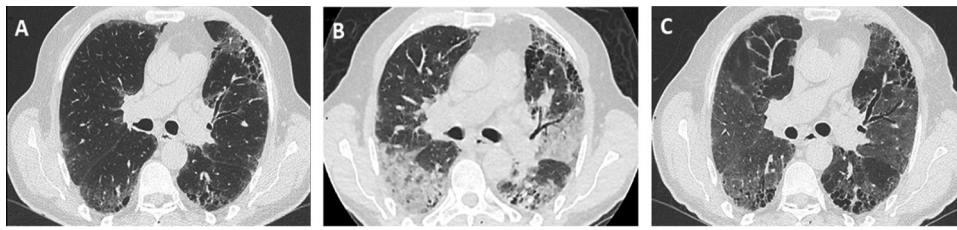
Chest computed tomography. A. September 2019; B. March 2020; C. April 2020.
